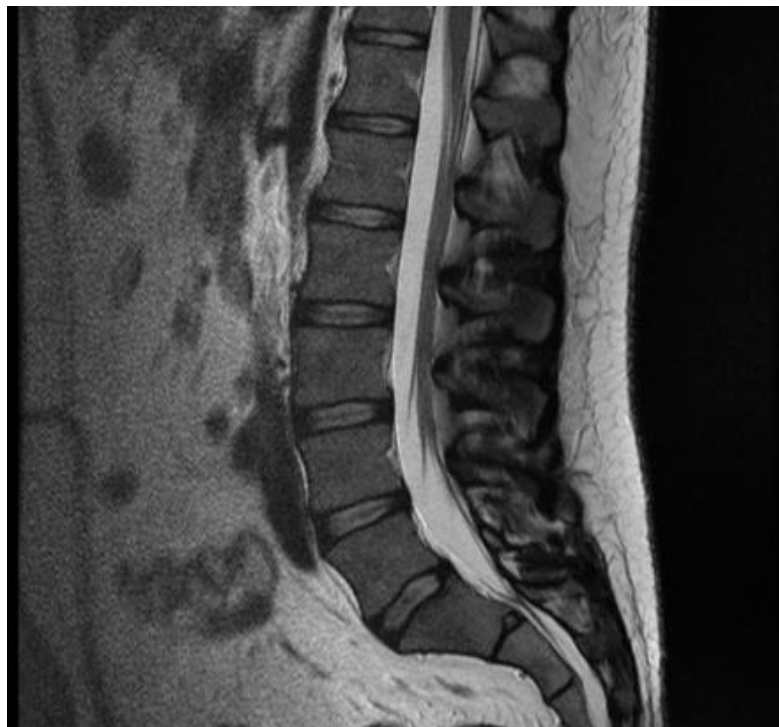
normal lumbar MRI
